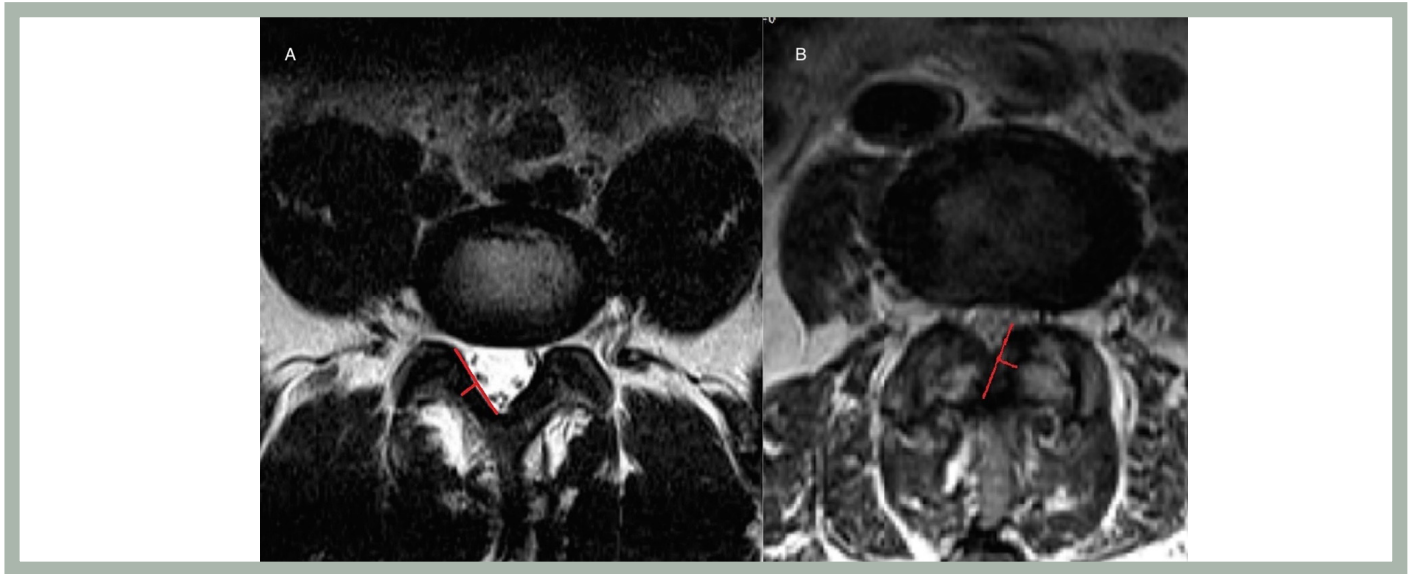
Left (A): axial T2-weighted MRI in a patient with isthmic spondylolisthesis showing that ligamentum flavum thickness is not increased and there is no facet degeneration in the adjacent segment. Right (B): axial T2-weighted MRI in a patient with degenerative spondylolisthesis showing that ligamentum flavum thickness is increased and there is facet degeneration in the adjacent segment
